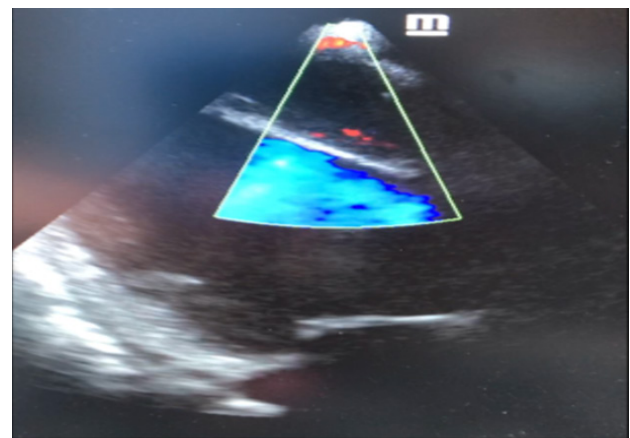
Echocardiography image showing absent color flow doppler effect inside neo-cavity
